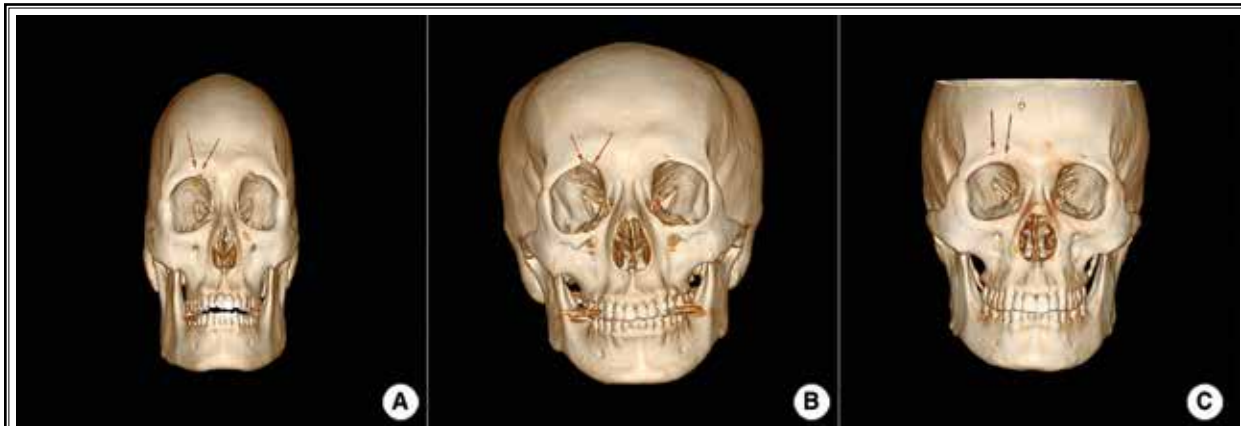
Facial bone 3D CT image showing supraorbital double types. Red arrow indicates the coexistence of supraorbital notch and foramen (A), notch and notch (B), and foramen and foramen (C).
